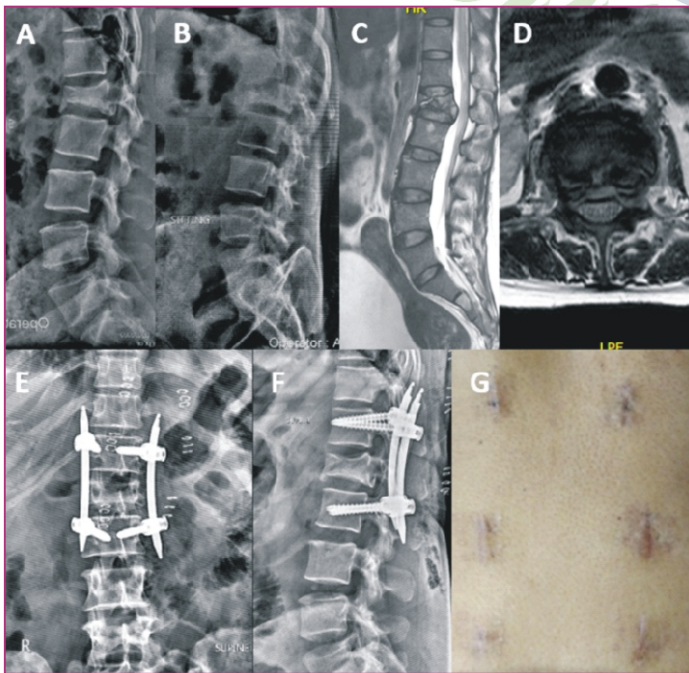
(Metastasis): Figure A & B (X-ray-Lateral view) - greater than 50% collapse of the central vertebral body of L1, Figure C and D (MRI) Bilsky grade 1c epidural cord compression, Figure E and F - percutaneous placed pedicle screw instrumentation, Figure G - Clinical photograph displaying the scars.
